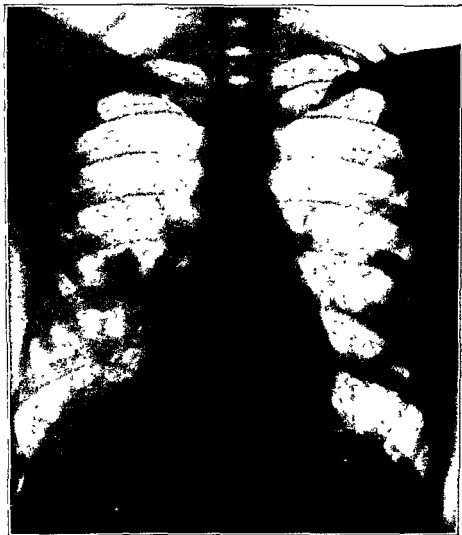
X-ray of Case No. 1 showing the extent of resolution after 41 days. The annular shadow has disappeared.
